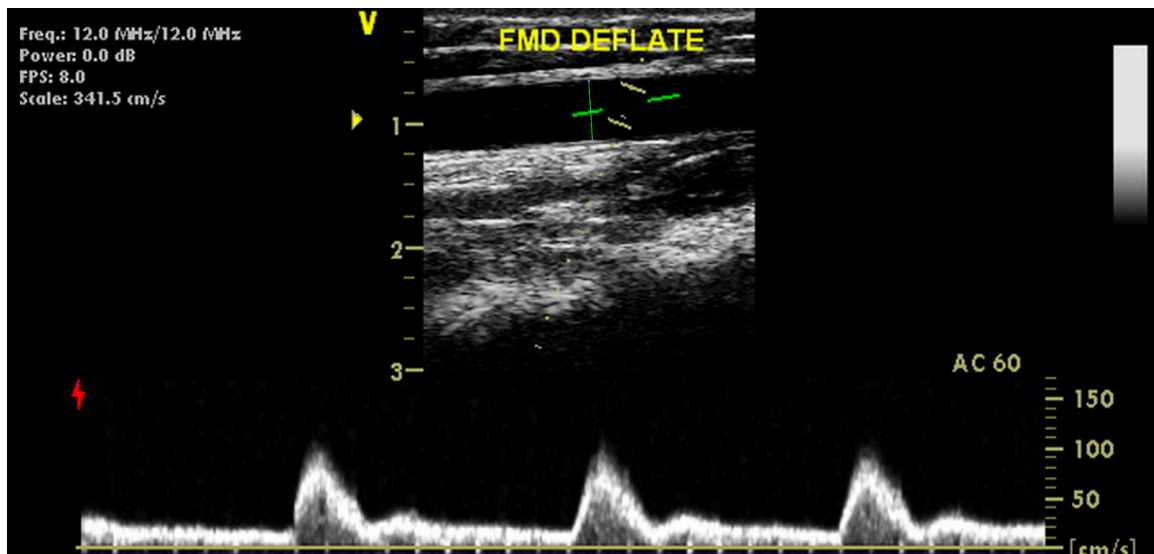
Ultrasound image viewed offline in OsiriX, depicting both the clean brachial artery diameter (top) as well as blood flow velocity profiles during FMD deflation (bottom). FMD, flow-mediated dilation.
